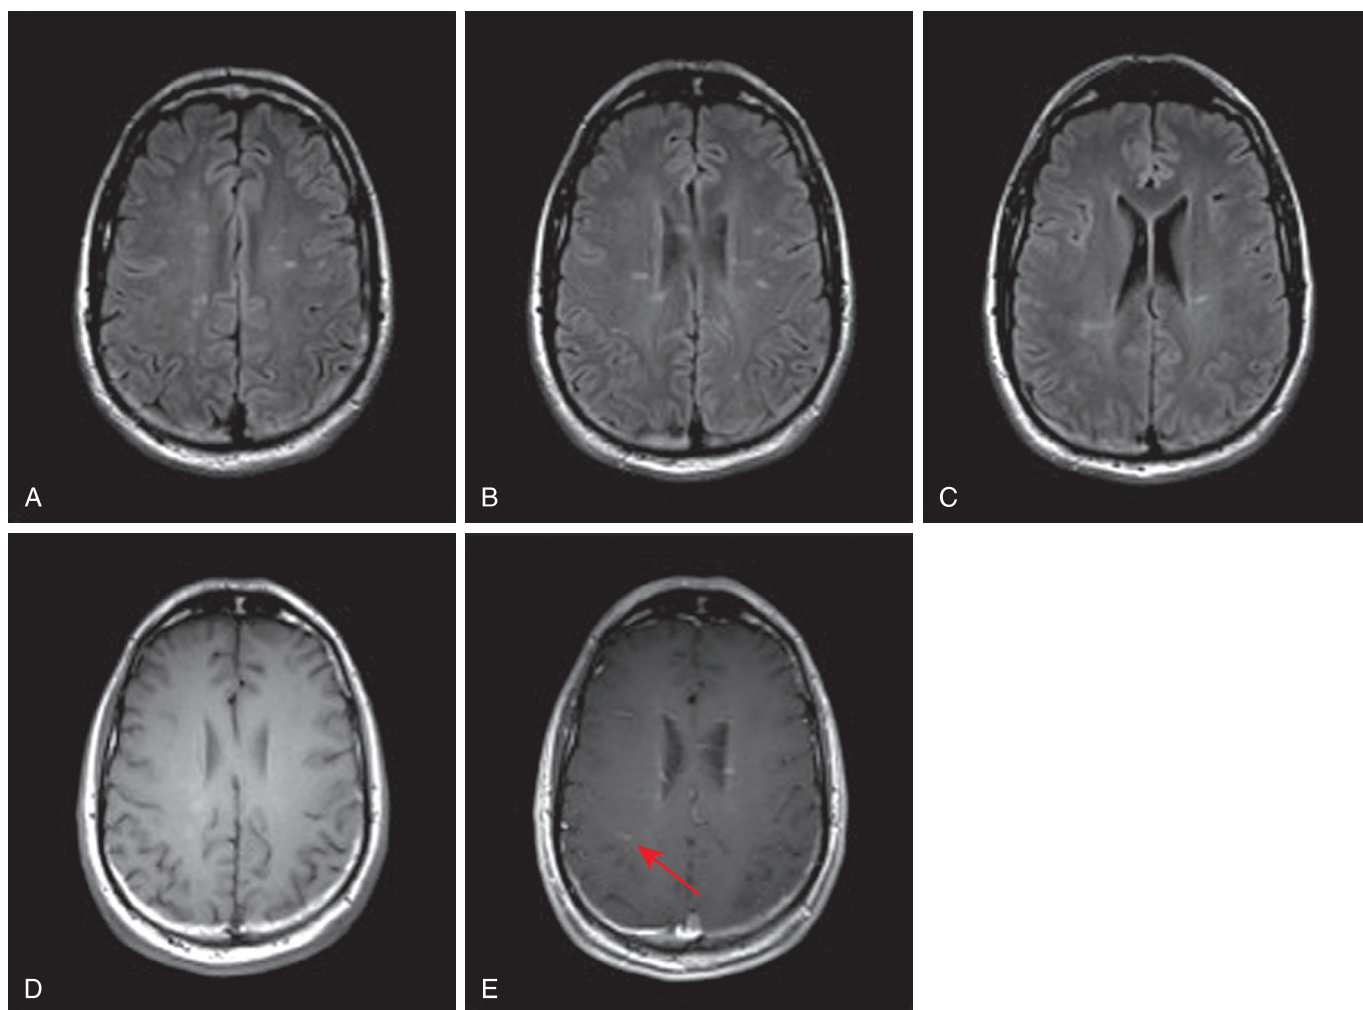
Multiple sclerosis (MS) case example. A 36-year-old male diagnosed with MS. Axial FLAIR (A–C), axial T1 precontrast (D), and axial T1 postcontrast (E) images demonstrate multifocal white matter lesions involving the periventricular white matter and corpus callosum with some lesions demonstrating enhancement (*arrow*).
